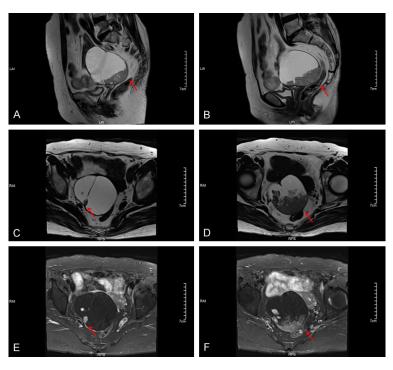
Typical mature cystic teratoma case. A, B. T1WI sagittal; C, D. T1WI axial; E, F. T2WI; T1WI: T1-weighted imaging; T2WI: T2-weighted imaging.
